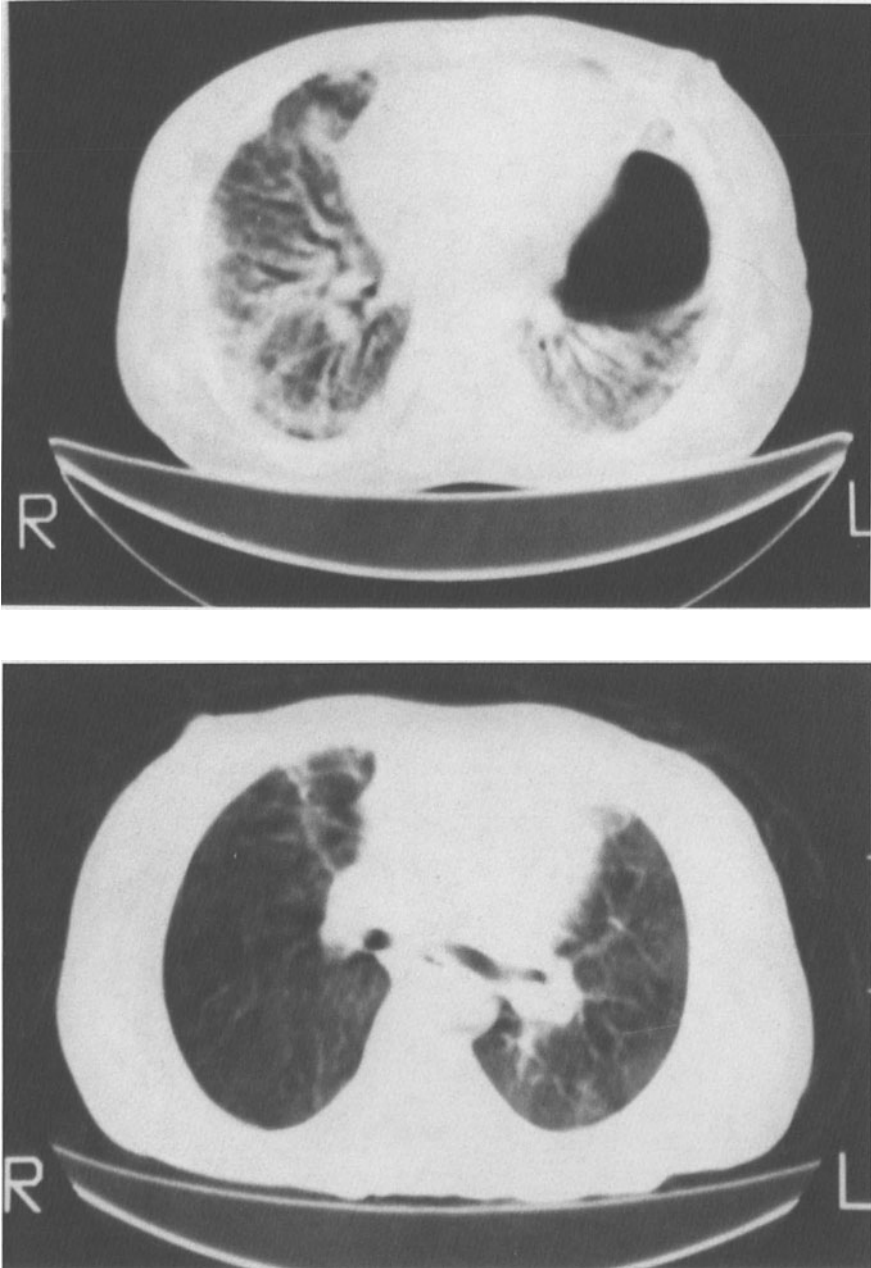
CT scans showing resolution of ARDS associated with pneumococcal pneumonia. (A) Pneumonia and resulting ventilator-induced barotrauma in an 18-year-old woman with sickle cell anemia. (B) Repeat chest CT scan 11 months after recovery.
